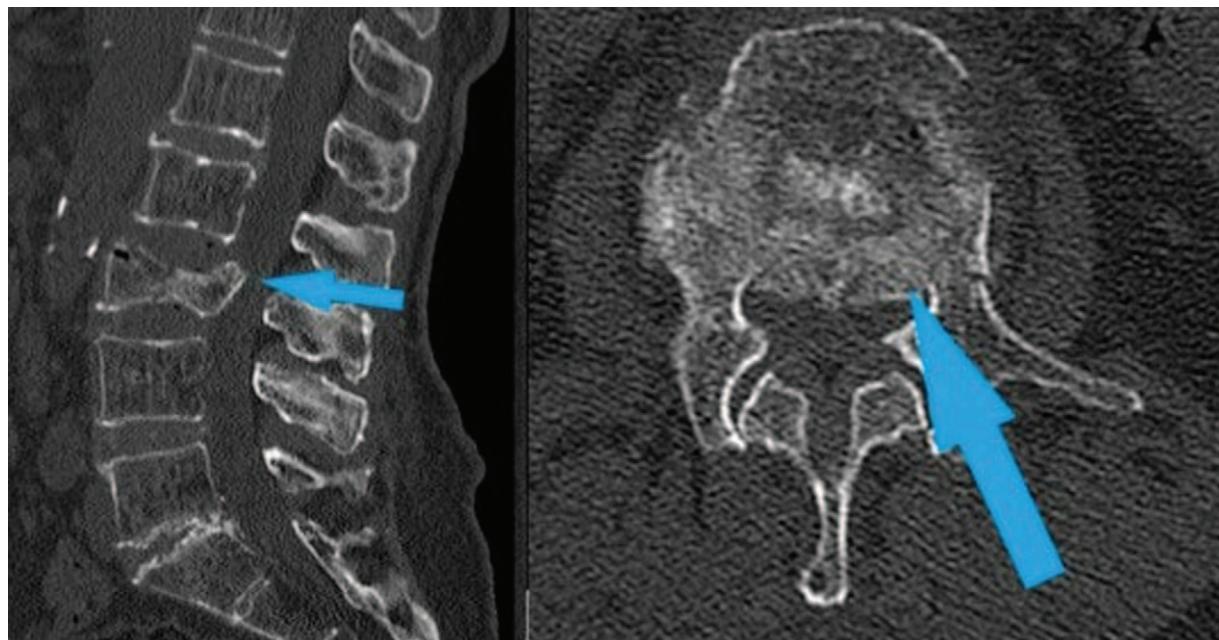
Preoperative CT (sagittal-axial) (blue arrows).
